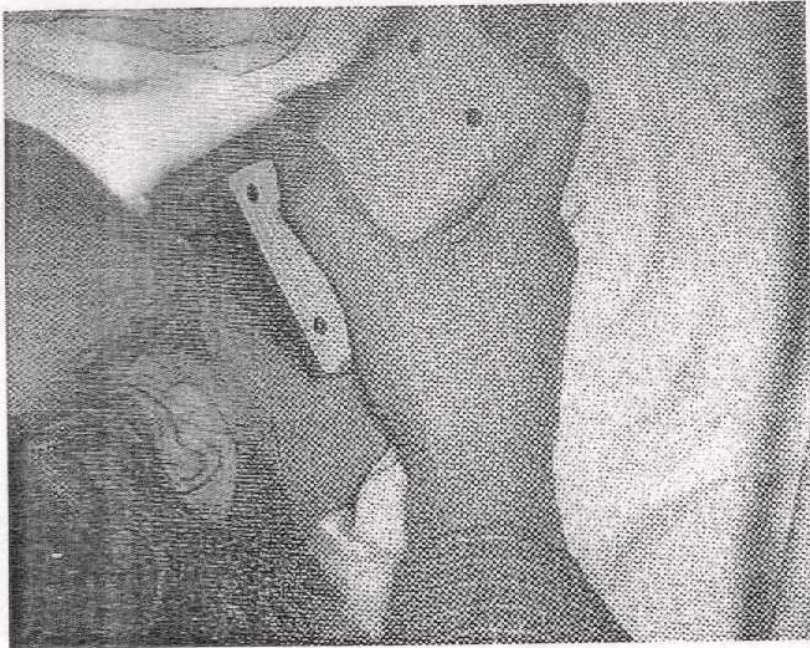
Transducer positioning for transverse imaging plan (*Quoted from Diagnostic ultrasound, 1998*).
